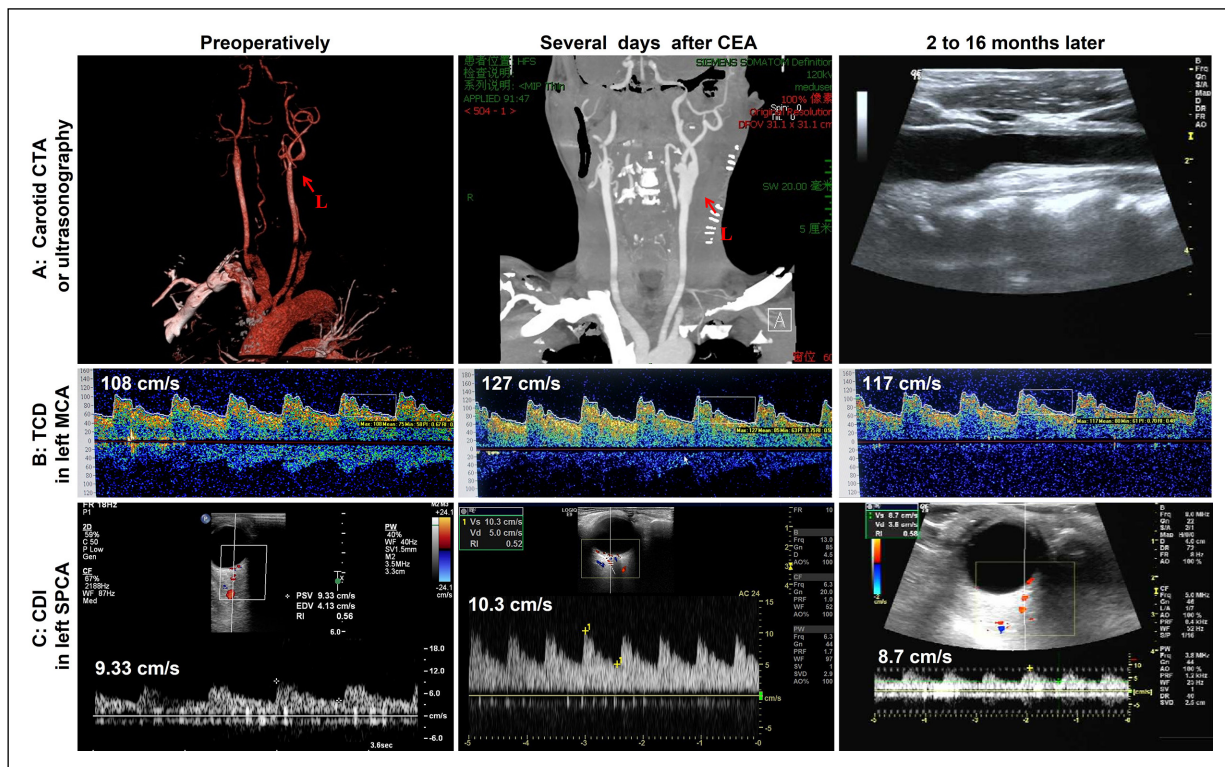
Image data acquired from a 62-year-old man with left 85% carotid stenosis. A, Left-sided CEA was successfully performed to resolve carotid stenosis, and good patency of carotid artery was confirmed by postoperative CTA and three-month follow-up color Duplex ultrasound scanning. B, The BFVs of left MCA increased from 108.0 cm/s to 127.0 cm/s at three days postoperatively, and eventually decreased to 117.0 cm/s at the follow-up of three months following CEA. C, The BFVs of left SPCA increased from 9.3 cm/s at three days postoperatively, and eventually decreased to 8.7 cm/s at the follow-up of three months following CEA. CEA, Carotid endarterectomy; CTA, computed tomography angiography; BFV, blood flow velocity; MCA, middle cerebral artery; SPCA, short posterior ciliary artery.
